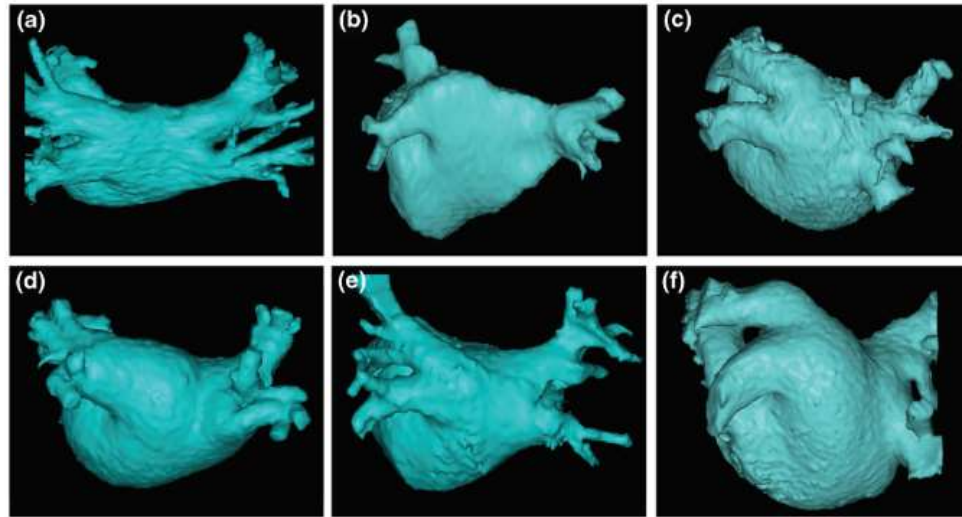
Posterior View of Left Atrium, Reconstructed from CT/MRI Data.
